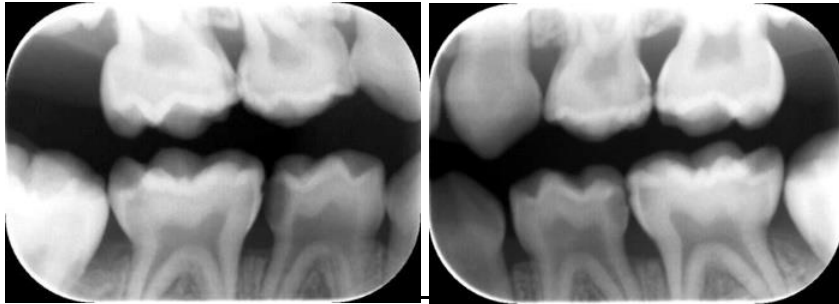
Case scenario 1. Bite-wing radiographs of a 5-year-old girl with pain due to severe caries.
